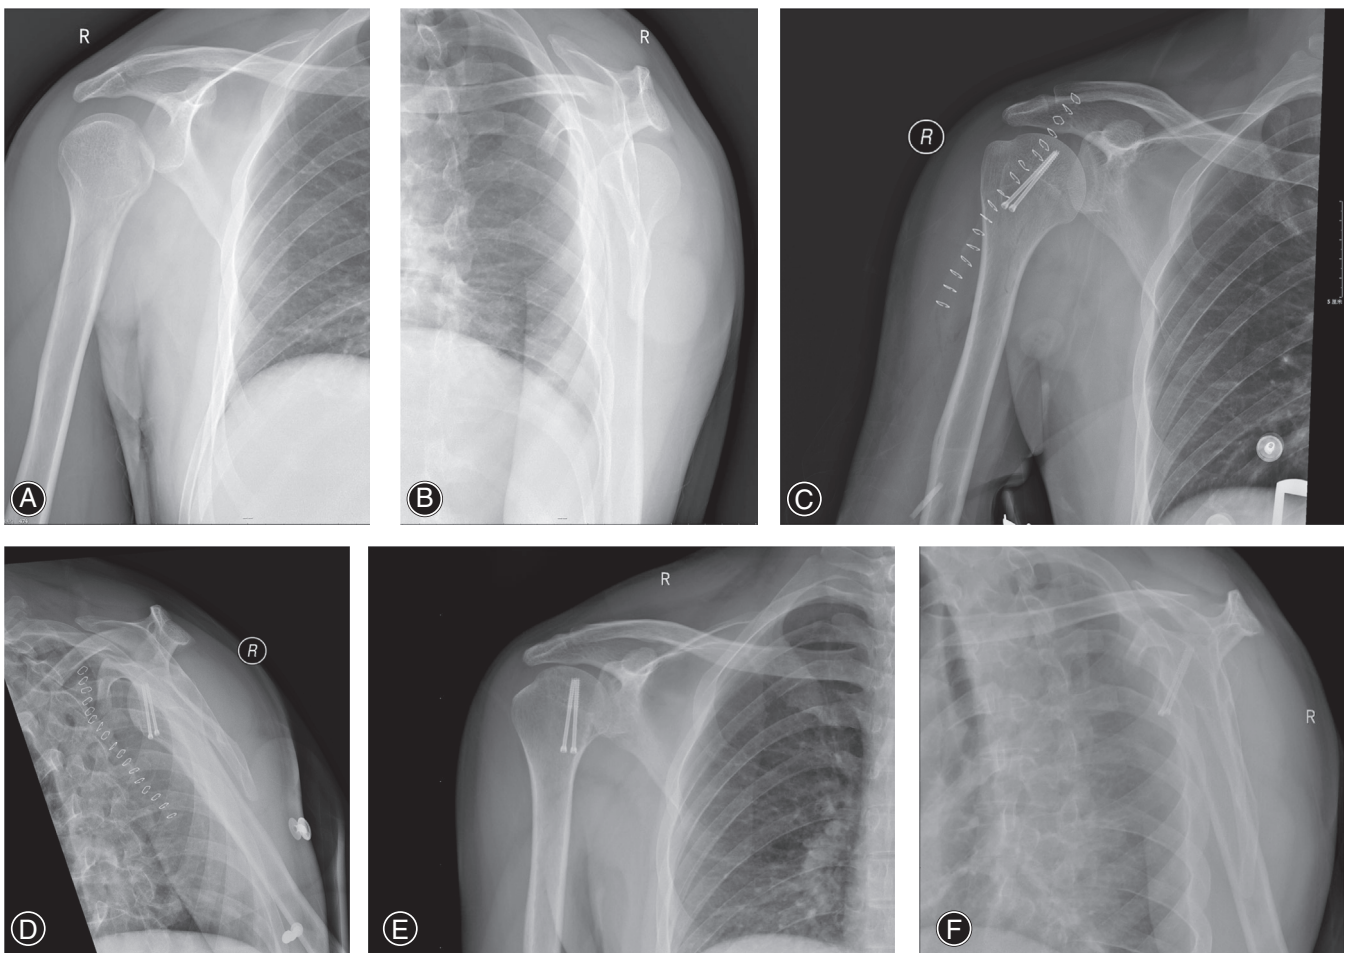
AP and scapular-Y view plain radiographs. (A, B) Preoperative images; (C, D) Images immediately after operation; (E, F) 3 month postoperative images.
